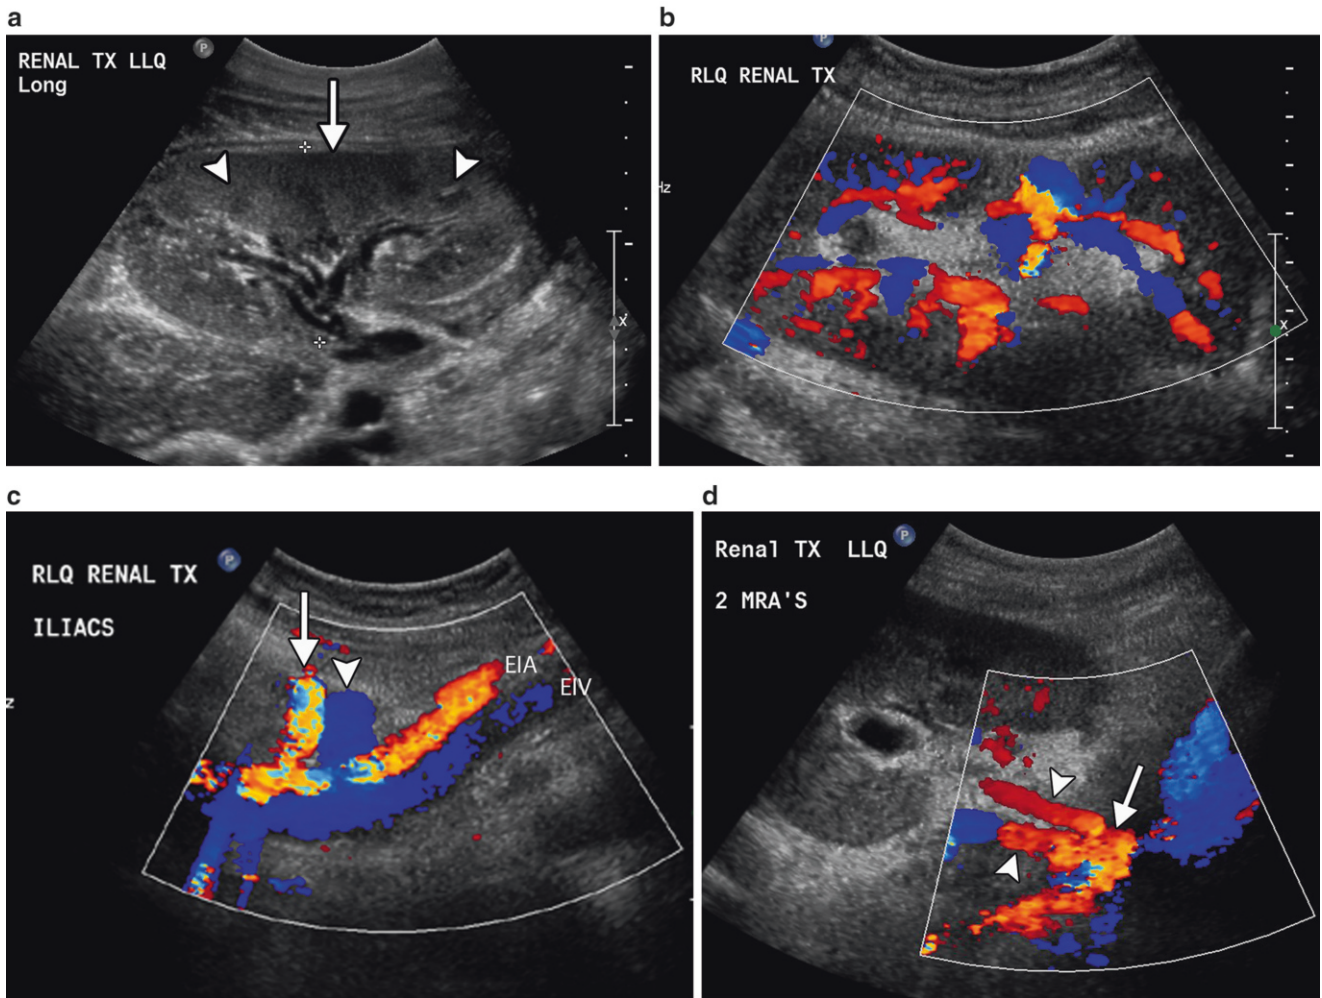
Normal ultrasound. (a) Normal gray scale ultrasound obtained in the long axis through the renal transplant. The renal sinus is the bright central echo containing vessels and renal pelvis. It is surrounded by the gray hypoechoic cortex (*arrow*) with darker pyramids (*arrowheads*) at the corticomedullary junction. (b) Longitudinal color Doppler image shows flow throughout the allograft. (c) Longitudinal
